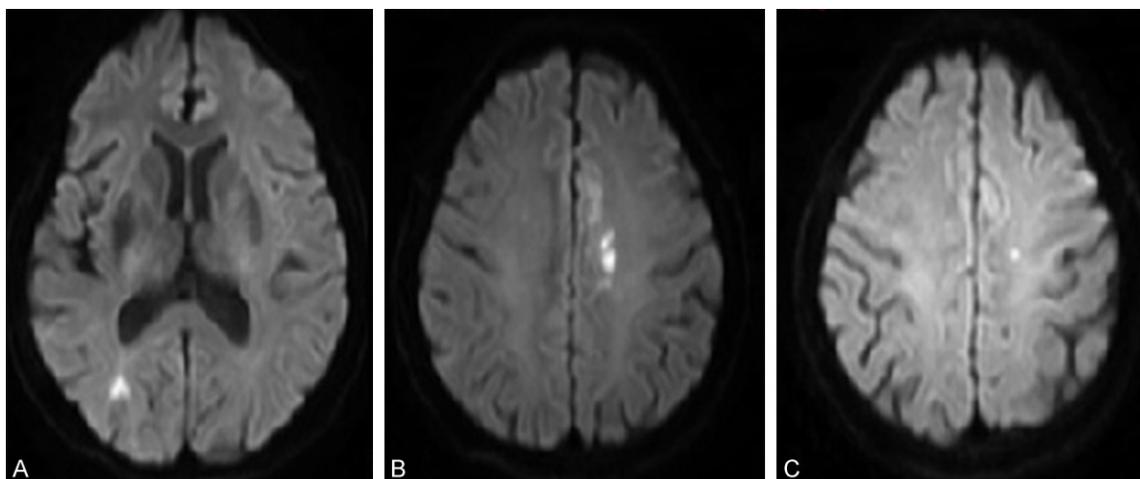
Cranial MRI diffusion weighted imaging (DWI) of Case 13. Multiple infarction lesions - A: 1 lesion in right occipital lobe; B: 1 lesions in left centrum semiovale; C: 1 lesion in left parietal lobe.
